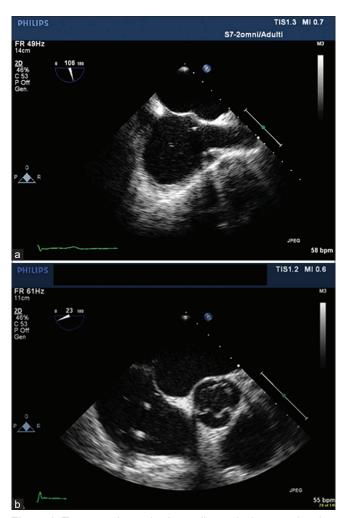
Transesophageal echocardiography images showing transseptal puncture of the central region of the septum during an appendage occlusion procedure. (a) Bicaval view. (b) Short-axis view
